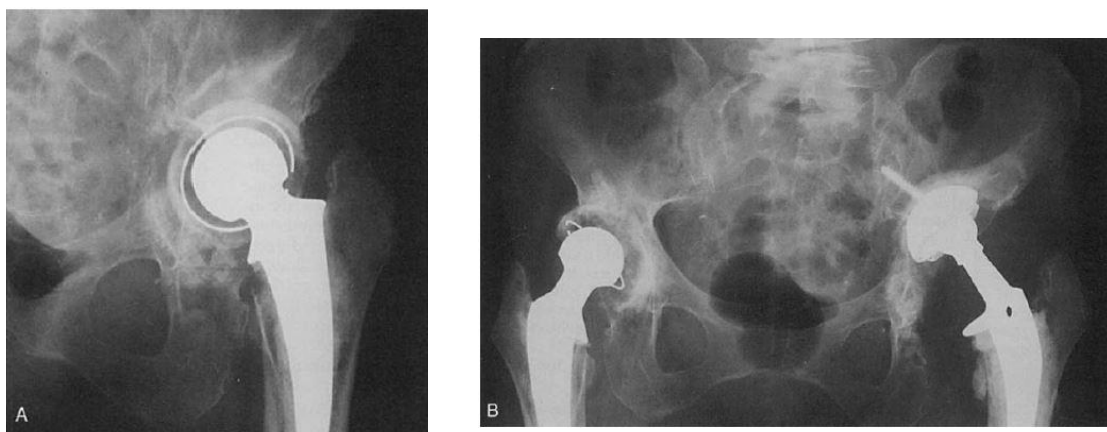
A, Preoperative radiograph of a failed cemented acetabular component with severe acetabular bone loss and fracture. B, Postoperative radiograph showing acetabular component placed at a high hip center ⁽³⁹⁾.
